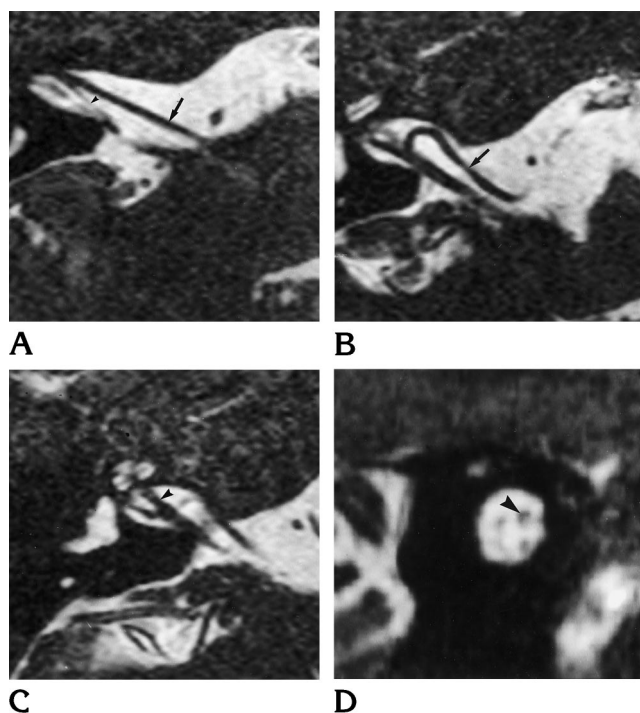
Normal findings. Noncontrast high-resolution T2-weighted (12.3/5.9/2 [repetition time/echo time/excitations]) MR examination obtained with 3-D Fourier transform constructive interference in the steady state (CISS). Flip angle was 70°, imaging matrix was 230 × 512.
